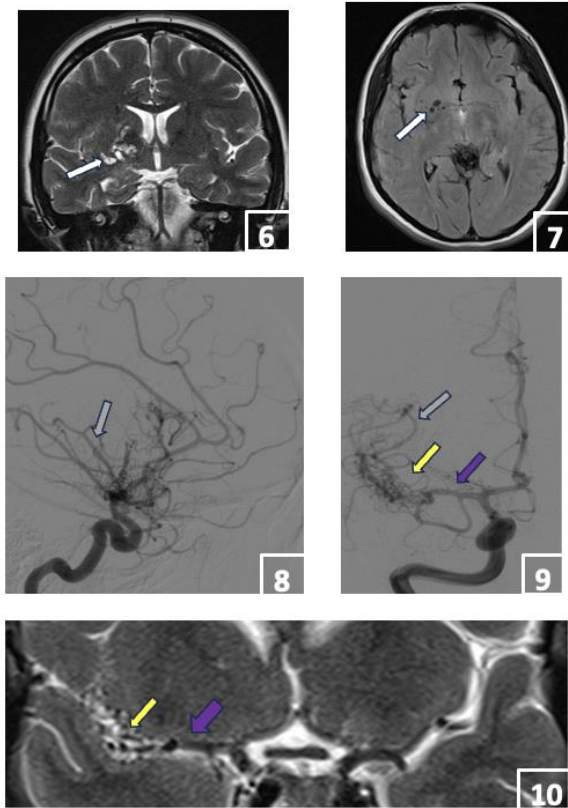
Case 2. Image 6: Coronal T2-weighted MRI showing hyperintense lesions in the basal ganglia, centered around a vessel (white arrow). Image 7: Axial FLAIR MRI showing multiple circular hypointense lesions of different sizes in the right basal ganglia (white arrow). Image 8: Profile cerebral angiography showing a plexiform network around the MCA bifurcation, with small distal cortical MCA arteries marked by the grey arrow. Image 9: Frontal cerebral angiography with right carotid contrast showing an M1 trunk measuring 24 mm, a pre-bifurcation MCA branch arising from the middle of the trunk (purple arrow), a plexiform network of small vessels beyond the trunk (yellow arrow), and distal MCA cortical branches (grey arrow). Image 10: Coronal T2-weighted MRI showing the M1 trunk (purple arrow) followed by a plexiform network (yellow arrow).
